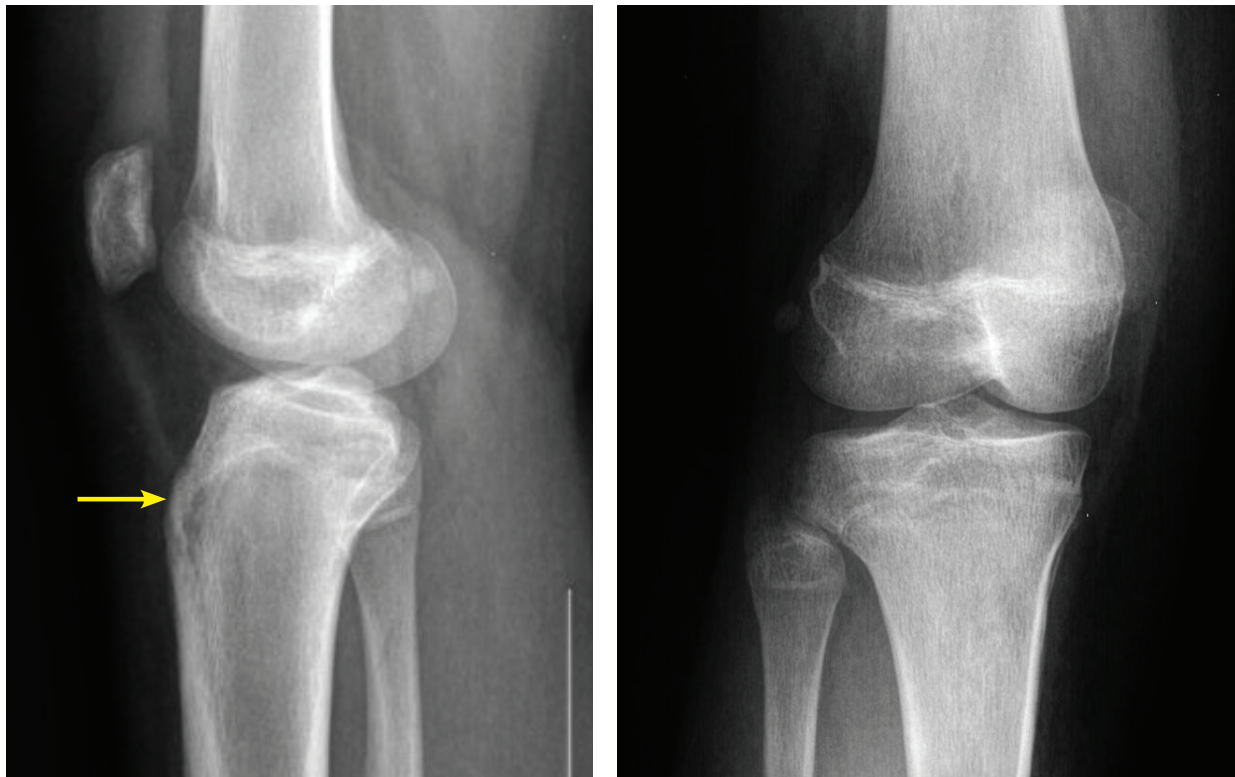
Lateral (A) and anteroposterior (B) radiographs of the right knee showing the healing process of the tibial tuberosity. Image obtained 10 weeks after the fracture.
